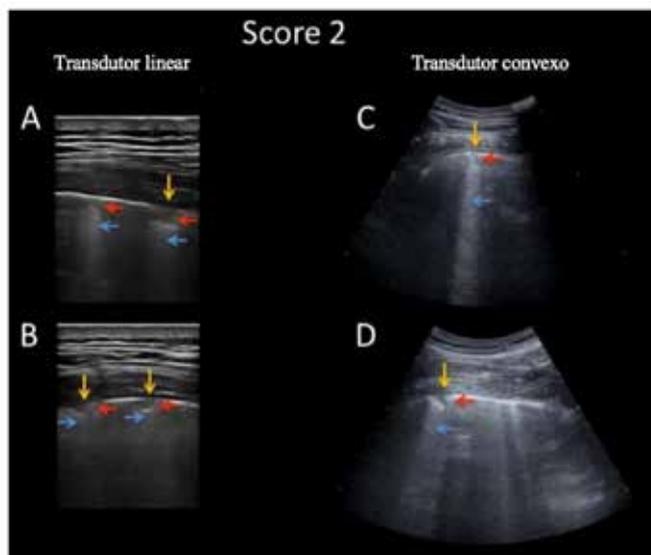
Pulmonary ultrasound images obtained with a linear (A-B) and convex (C-D) probe. The pleura line is severely broken. Below the point of discontinuity (indicated by the orange arrows), small consolidated areas (darker areas indicated by the red arrows) appear with associated white areas (indicated by the blue arrows) in correspondence with the consolidations. This standard is classified as Score 2⁶.
